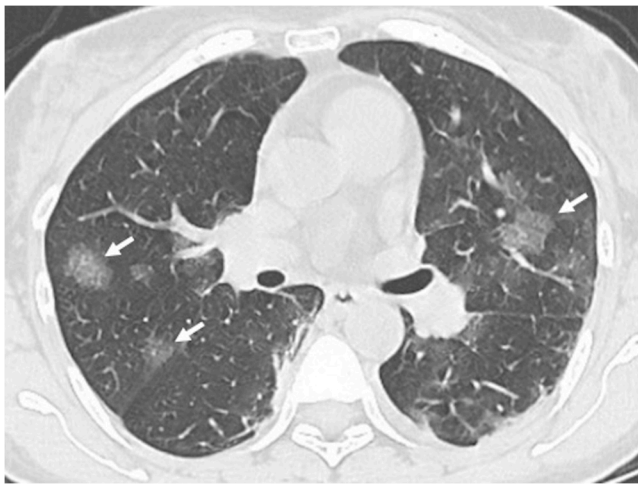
59-year-old male with confirmed Covid-19 pneumonia. Axial CT image shows nodular round ground glass discrete opacities bilaterally (arrows).
